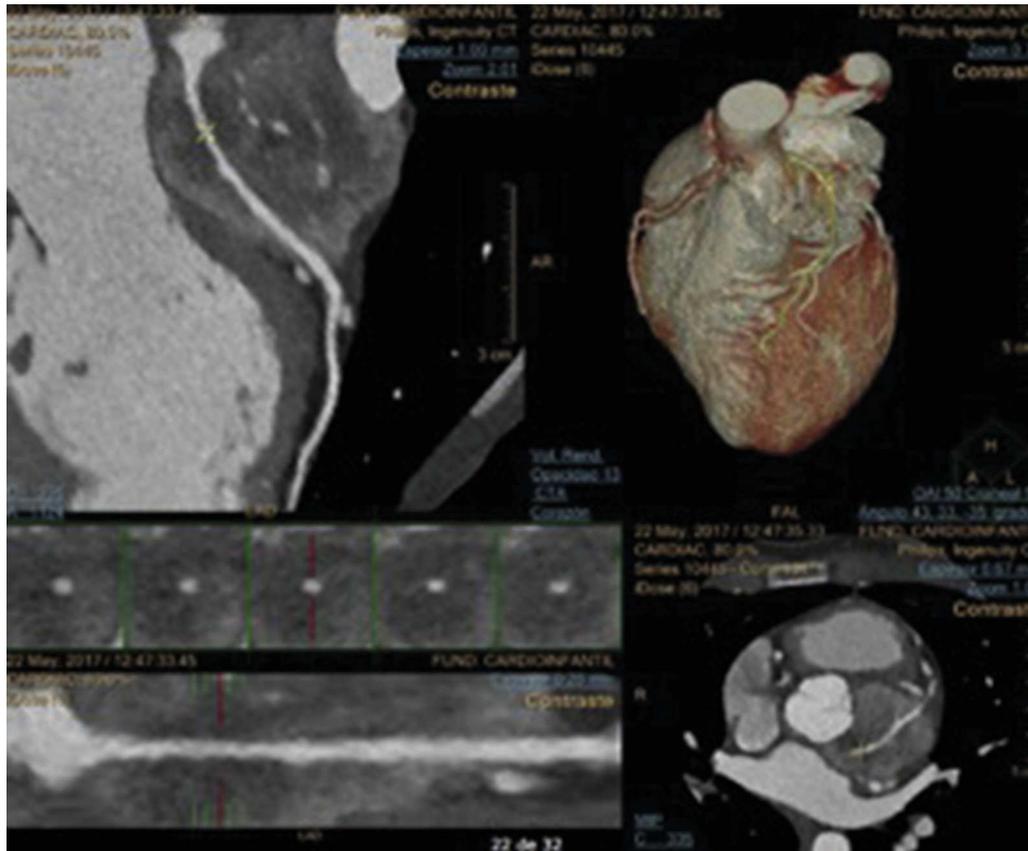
Coronary computed tomography. Mass surrounding the left main coronary artery and the proximal segment of the anterior descending and the circumflex coronary arteries.
